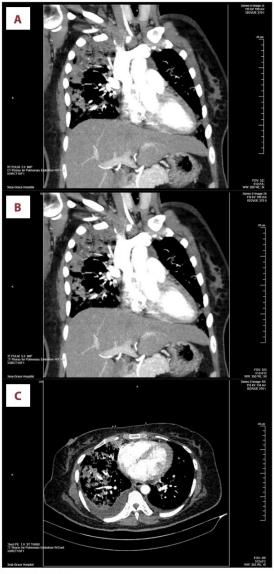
(A-C) Computed tomography angiography demonstrating multiple emboli involving segmental and subsegmental pulmonary arteries in the left lower and upper lobes and the left lower lobe lobar artery and subsegmental emboli in the right upper lobe. No large central emboli.
